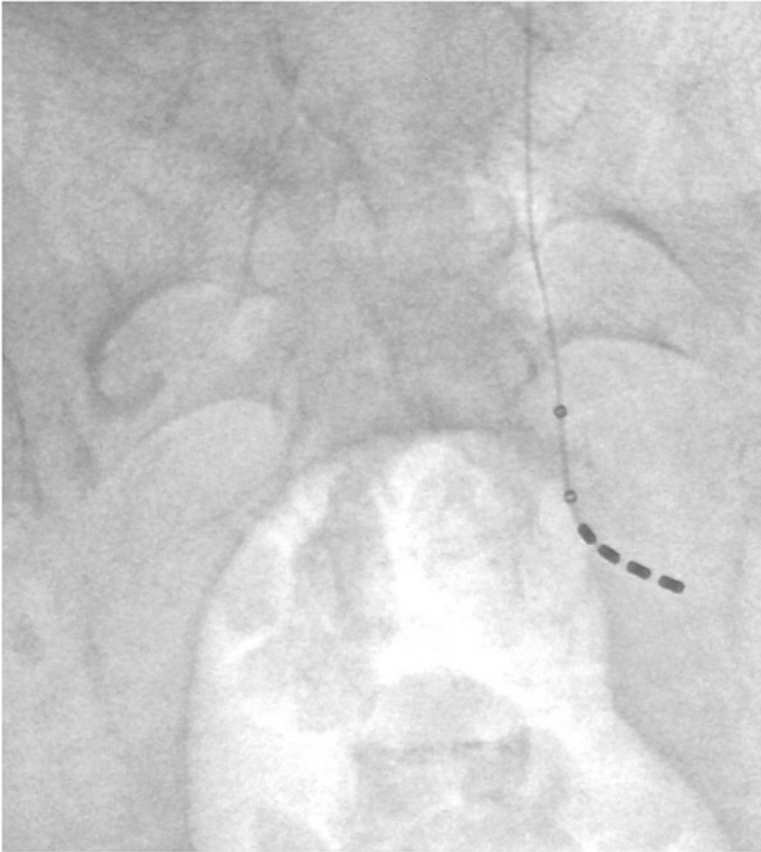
Ideal A-P x-ray. Reprinted with permission from Medtronic
